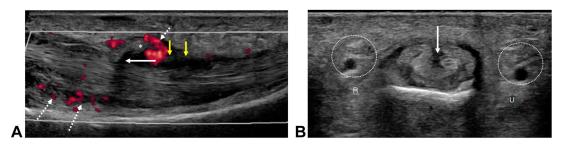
A Longitudinal power Doppler and B transverse gray-scale ultrasound images of the ring finger volar aspect at the level of the proximal phalanx. There is a 50% partial thickness longitudinal laceration of the FDP (*solid arrows*), yielding a superficially displaced flap of tissue (*). Tenosynovitis is characterized by hyperemic, thickened tenosynovium, and trace fluid is elicited (*dashed arrows*). The A2 pulley is thickened (*yellow arrows*). Radial, R; ulnar, U; digital neurovascular bundles (*dashed circles*).
